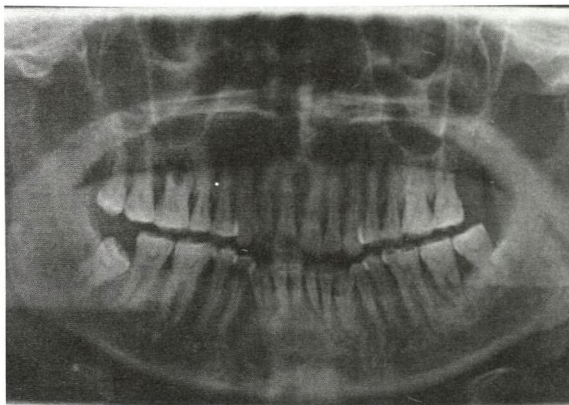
1 year post operative panoramic radiograph.
